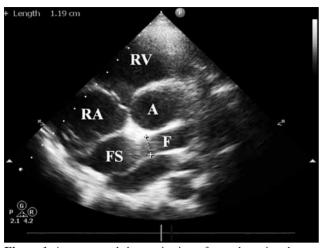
A parasternal short axis view of transthoracic echocardiography showing a coronary fistula draining into the right atrial cavity through a fistula tract.
